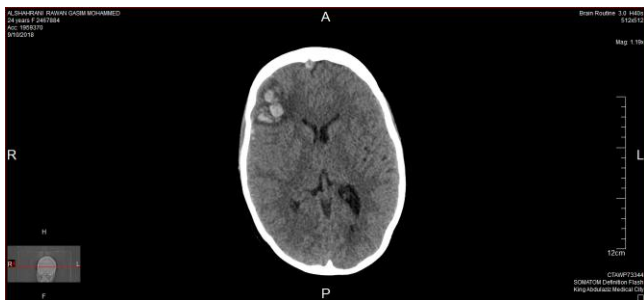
A CT venogram showed SSS thrombosis, with a right frontal lobe haemorrhagic insult and mild surrounding vasogenic oedema, in addition to a mass effect over the adjacent sulci and right lateral ventricle
